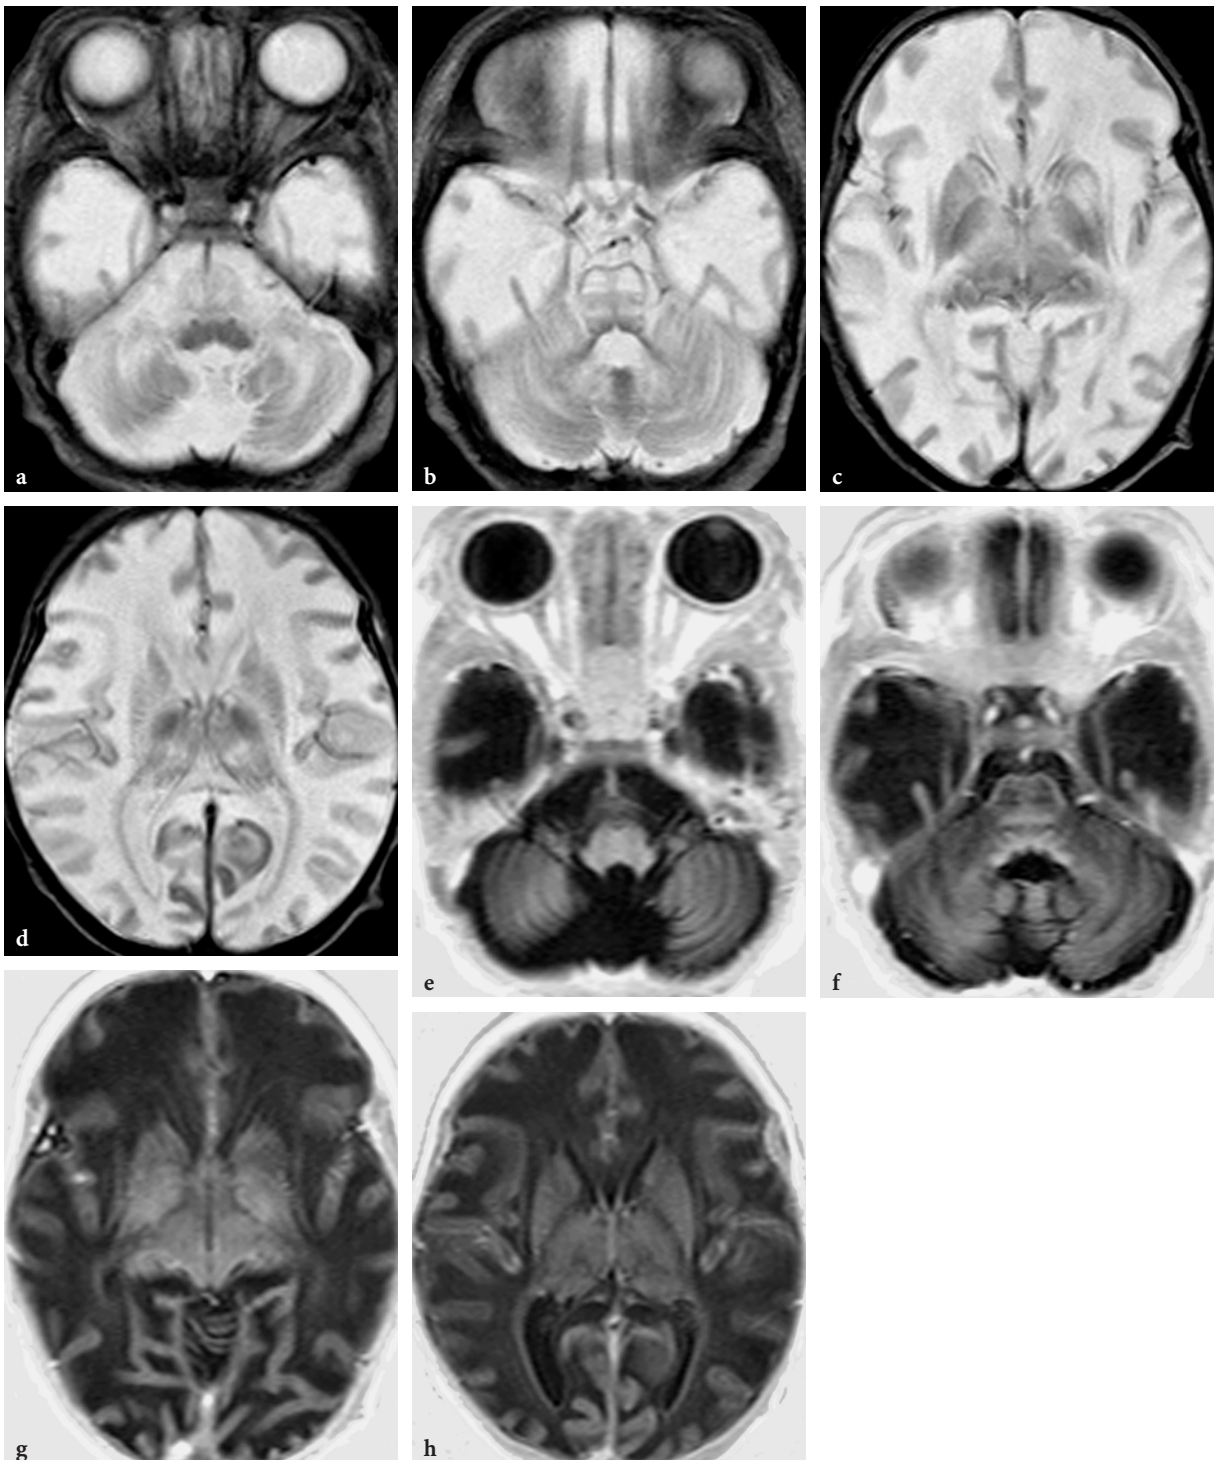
a–h. MR imaging findings in metabolic crisis in urea cycle defect (carbamylphosphatase synthetase deficiency) in a 15-day-old male neonate. a–d Axial T2-weighted fast spin-echo images. Diffuse brain edema with extensive white matter signal changes, with relative sparing of myelinated structures (e.g., posterior brainstem structures). Abnormal hyperintensities are suggested within the thalami and the anterior part of the putamen on the right side. e–h Axial T1-weighted inversion recovery images. The relative sparing of the myelinated structures in the brainstem is better appreciated on these images. In some areas the cerebral cortex appears to be involved
